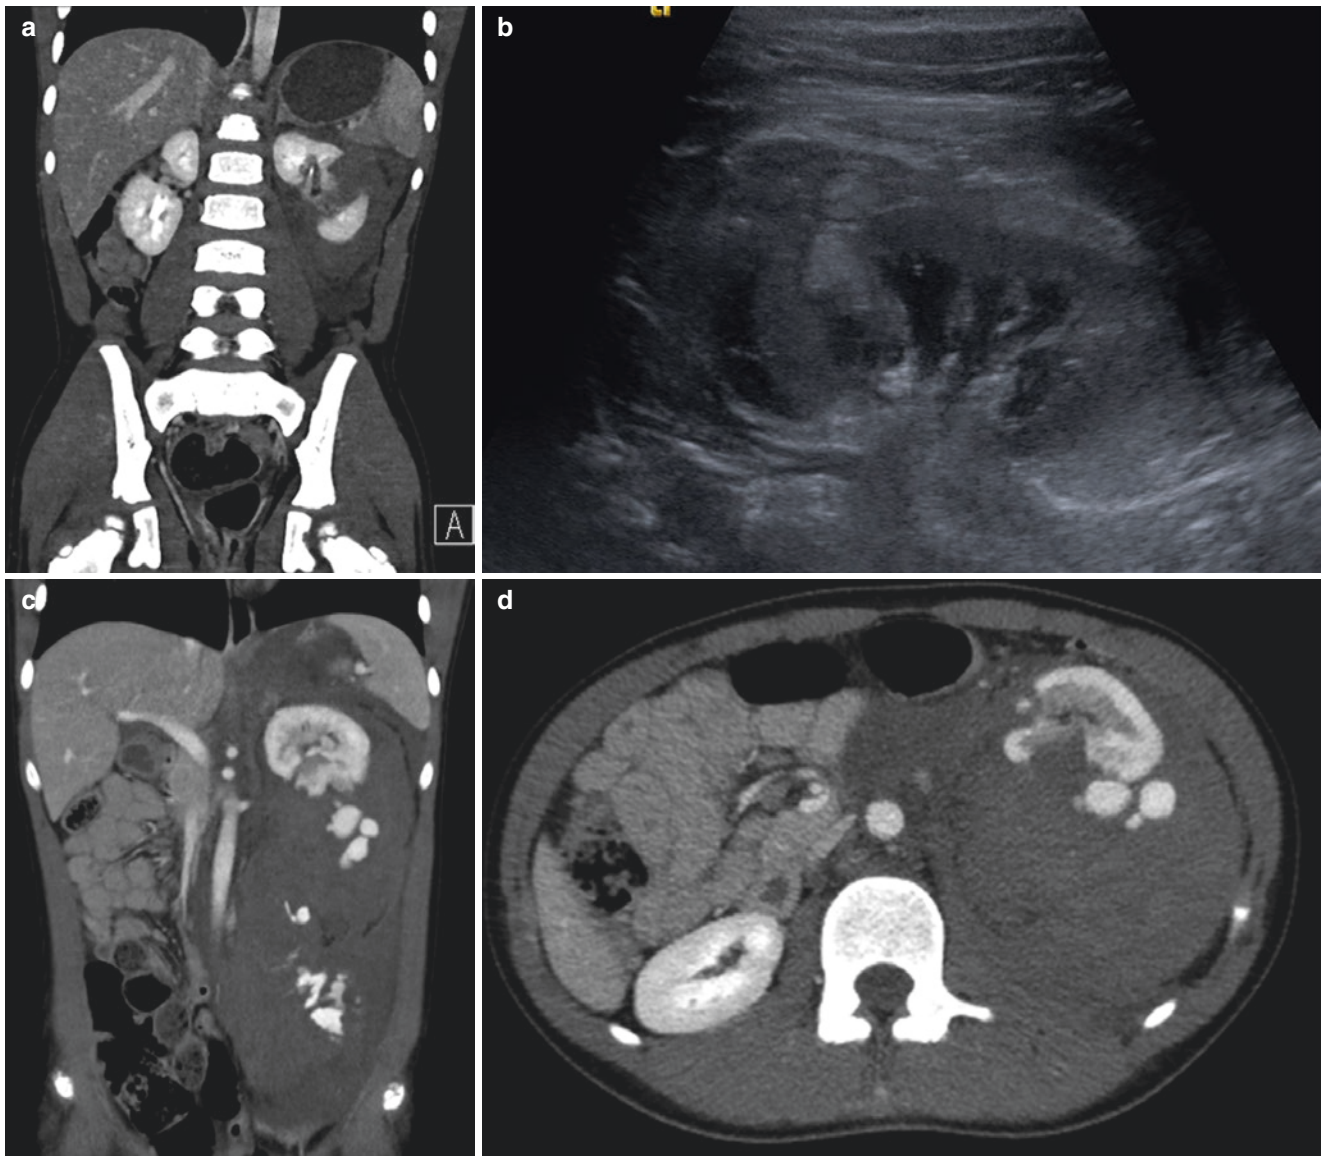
(a) Coronal contrast-enhanced CT. There is a laceration through the mid interpolar left kidney with a large perinephric haematoma. (b) Longitudinal ultrasound image of left kidney of the same patient as in (a). The renal laceration is visible as an echogenic avascular defect in the mid interpolar kidney, communicating with echogenic perinephric haematoma. (c) Coronal contrast-enhanced CT. High-grade
